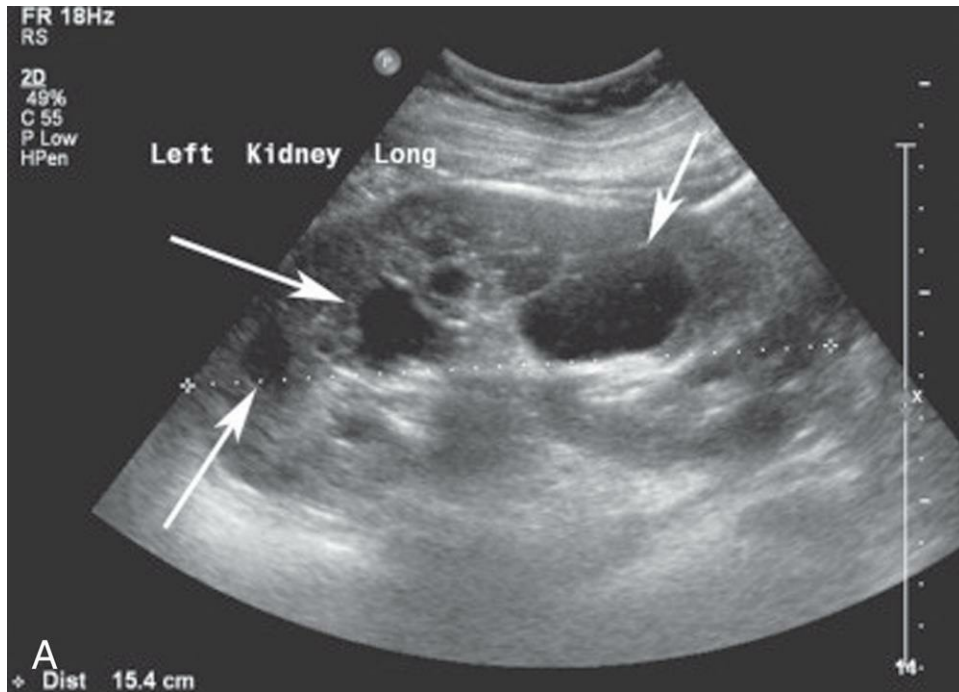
Autosomal dominant polycystic kidney disease. (A) Ultrasound of an enlarged left kidney in a child, showing multiple simple cysts (arrows) of varying size. (B) In the same patient, a coronal T2 gradient echo image showing multiple renal cysts throughout both kidneys. (Reproduced from Allan PL, Baxter GM, Weston MJ. *Clinical Ultrasound*. 3rd ed. Elsevier: 2011.)
